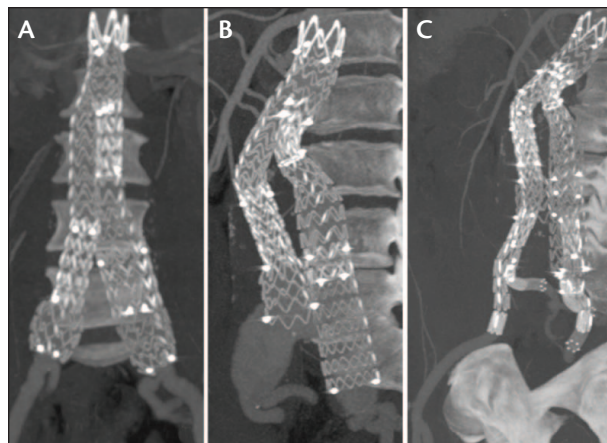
Postoperative CTA showing successful endovascular aneurysm exclusion using the bell-bottom technique for the right common iliac artery (A). Control CTA at 3 years revealing migration of the flexible right limb of the endograft with a type IB endoleak due to progression of aneurysmatic disease at the DSZ (B). Endovascular repair of the distal seal zone with bilateral implantation of iliac branch devices (C).
